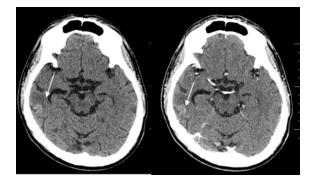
Another case of uncorrected diagnosed lymphoma by CT. Final diagnosis was proved by pathological report to be chronic inflammation
